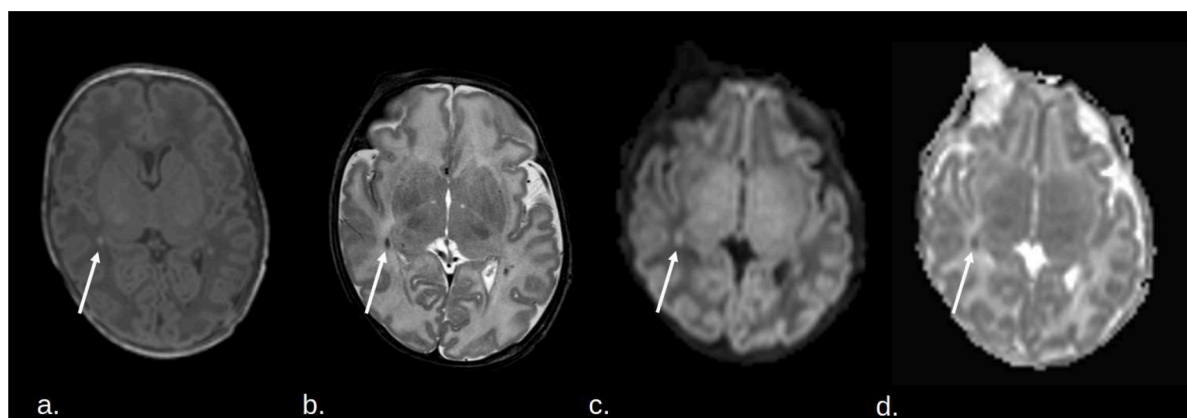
Brain MRI imaging of a neonate with EV infection. Punctate periventricular white matter lesion (white arrow) with the following characteristic: a) hyperintensity in axial T1-weighted image b) hypointensity in T2-weighted image, c) high signal on DWI and d) low signal on ADC sequences. DWI: diffusion weighted imaging. ADC: apparent diffusion coefficient of water.
